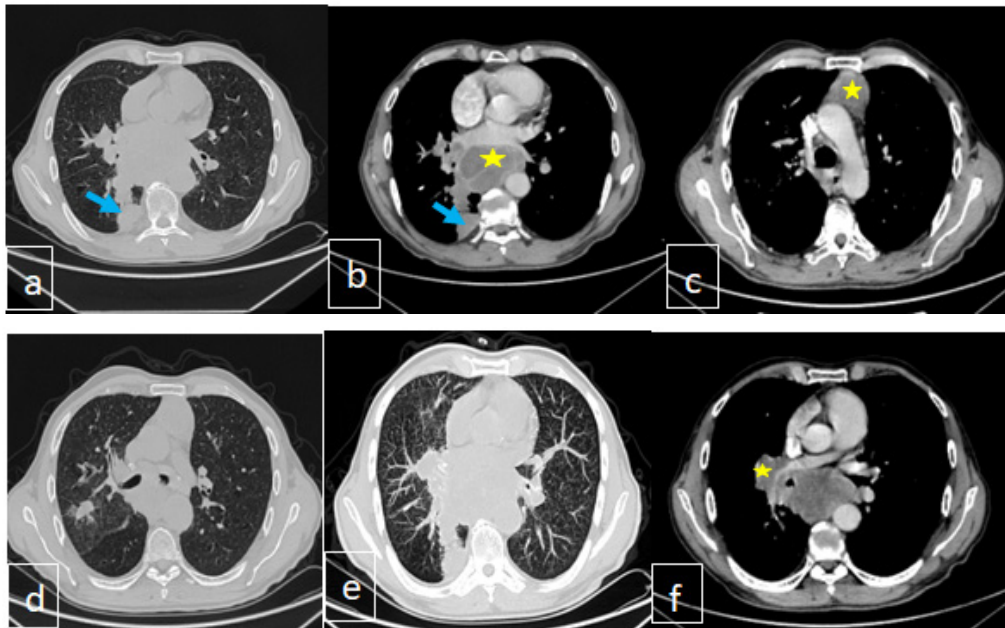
Thoracic CT scan axial sections, Lung parenchymal windows without PIM (a,b) and with PIM (e) showing a suspicious right mediastino-pulmonary tumor mass (blue arrow) with irregular contours, enhanced after contrast, measuring 54 × 47 mm in diameter. Associated with diffuse nodules and micronodules, randomly distributed, secondary in appearance. Mediastinal windows showing mediastinal ADPs (young stars) at the upper mediastinal level in pre-vascular (c), subcarinal (d) and right hilar level (f) encompassing the right pulmonary artery, realizing magma, heterogeneously enhanced after contrast, massively necrotic, secondary in appearance.
